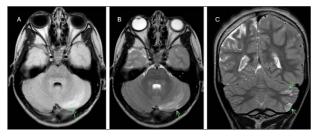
Crossed cerebellar diaschisis (A) Axial FLAIR image, T2-weighted image in axial(B)and coronal(C) planes demonstrate volume loss and patchy hyperintense signal abnormalities in the left cerebellar hemisphere, contralateral to the supratentorial abnormalities.
